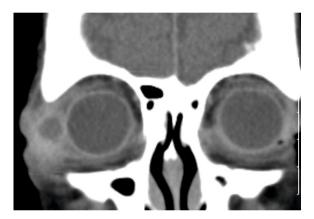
CT scan identifying an abscess within the lacrimal gland
